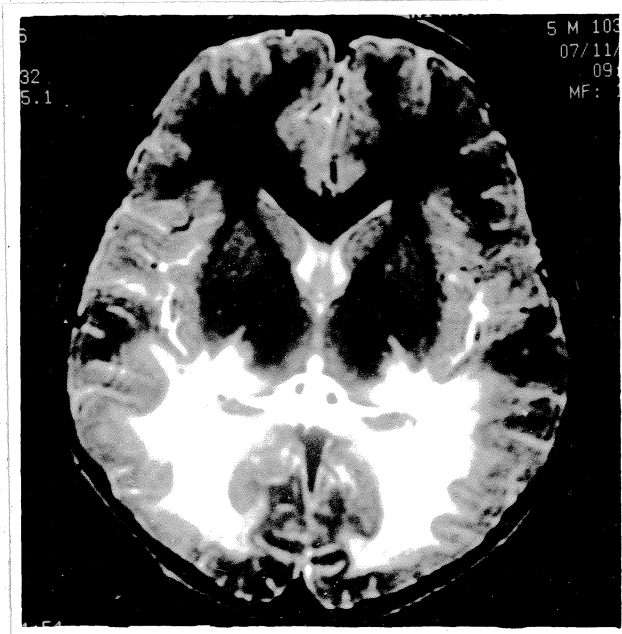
Parieto-occipital demyelination in a case of ALD (MRI T₂ WI).
